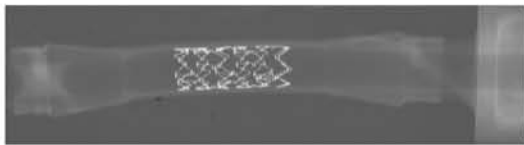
Radiographic image of stented BVM.
